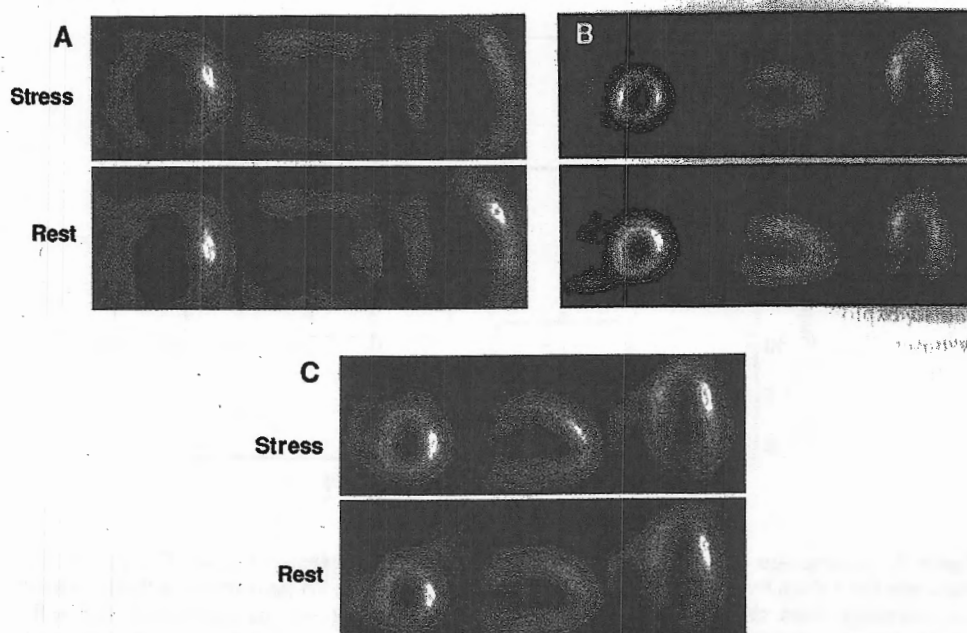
Categorization of HF etiology using Tc-99m sestamibi MPI. A, Left ventricular (LV) dilation (abnormal LV systolic function by gated SPECT not shown) with large, fixed perfusion defects in the septum, anterior wall, apex, and inferior wall suggestive of CAD-related ("ischemic") cardiomyopathy. B, Normal stress-rest perfusion and LV size (normal LVEF on gated SPECT not shown) indicative of HF likely related to diastolic mechanisms. C, LV dilation (with abnormal LV systolic function on gated SPECT, not shown) and normal perfusion suggestive of non-CAD related ("nonischemic") cardiomyopathy. The normal perfusion in the latter two categories has a high NPV for extensive CAD.
